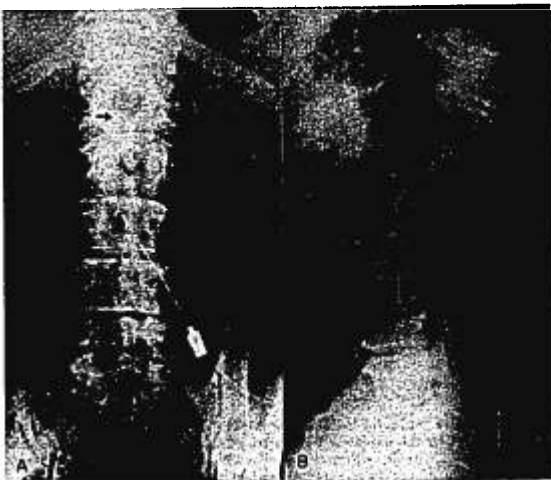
Photographs of roentgenograms showing the technique of continuous peridural block in the lumbar region. (a) Posterior anterior view with the peridural needle and plastic tubing in place. (b) Lateral view showing the plastic tubing within the spinal canal with its tip at the level of the caudal portion of the twelfth thoracic vertebra.
